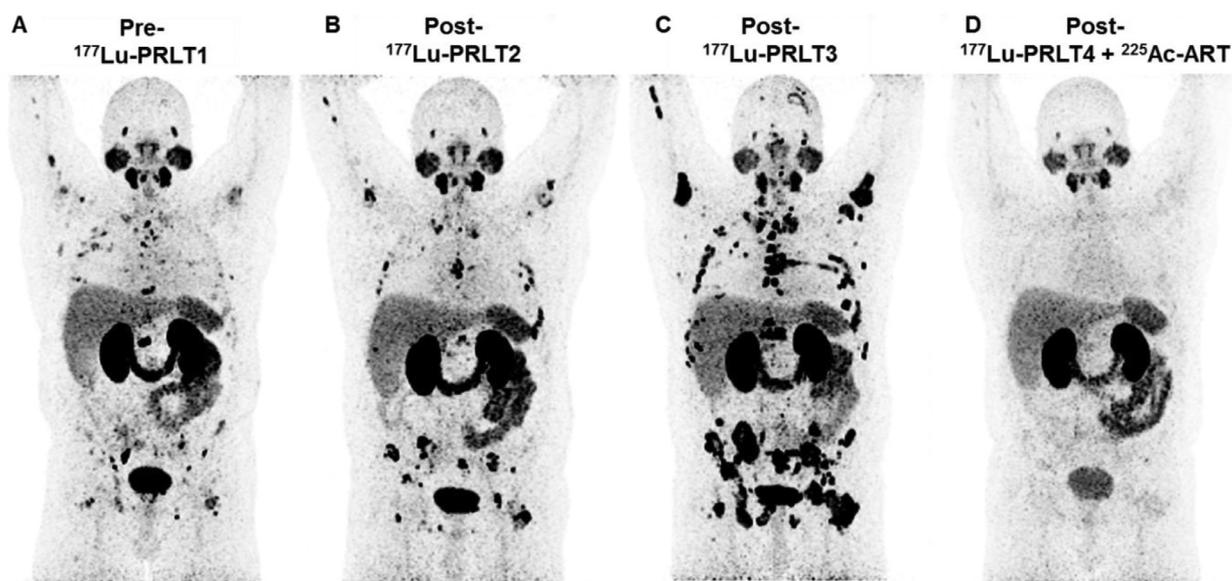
A 57-year-old patient (first diagnosis in 2012) with progressive mCRPC, and with extensive bone and lymph nodes metastasis, had undergone repeated ADT, chemotherapy, and external beam radiotherapy, who received three cycles of Lu-177 PSMA PRLT (cumulative administrated radioactivity 21.8 GBq) between April 2017 and October 2017, and then prognosed (A-C). In February 2018, the patient received TANDEM alpha-beta PSMA radioligand therapy (Lu-177 PSMA + Ac-225 PSMA), and achieved excellent response with complete remission (D). The treatment was very well tolerated and had no significant side effect.
